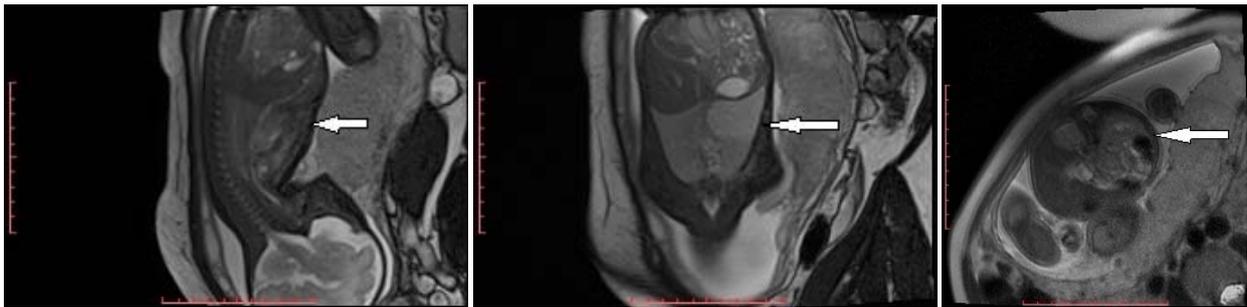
A, B, C. Fetal MRI revealing a 37/35 mm mass containing cystic structure at the base of the left lung
